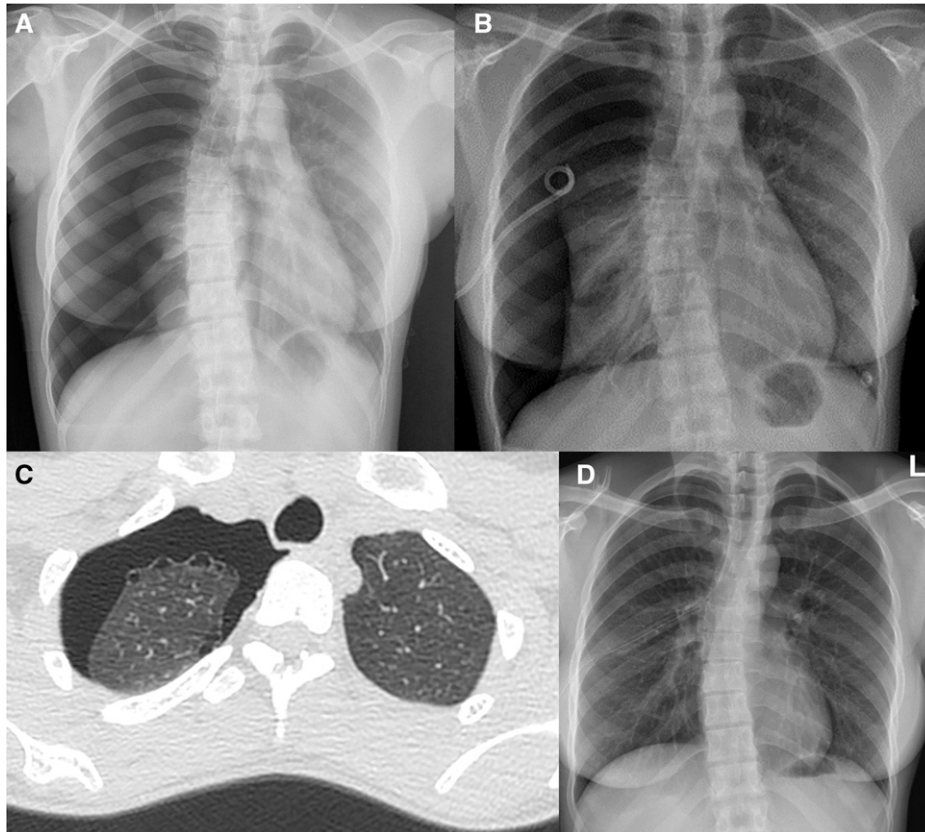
(A) Chest x-ray shows right-sided pneumothorax. (B) Intercostal catheter on the right side. (C) Chest CT shows large right-sided pneumothorax and bullae in the right lung apex. (D) Chest x-ray shows large-bore chest drain. CT = computed tomography.
